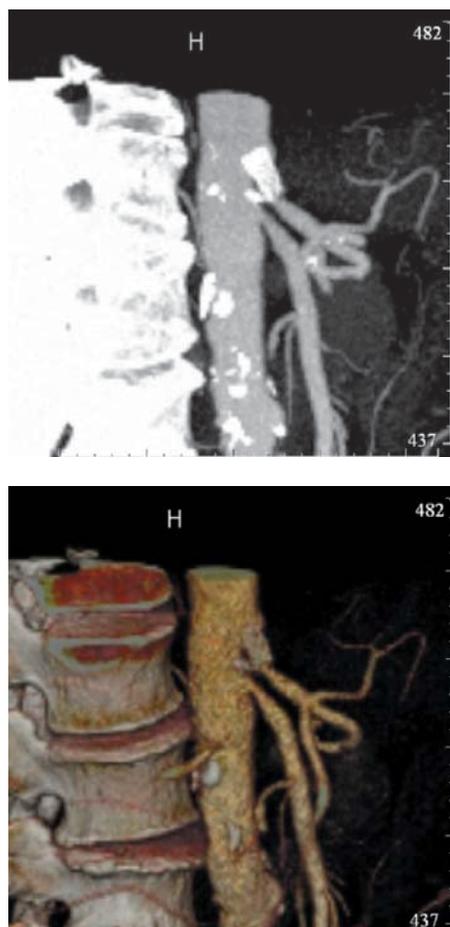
CT-angiography of the patient B., 6.10.2009, case history # 23,478. Condition after stenting of the celiac trunk, its lumen is patent, stenosis up to 50% is more distal than the stent, stenosis of superior mesenteric artery ostium is 40%.
